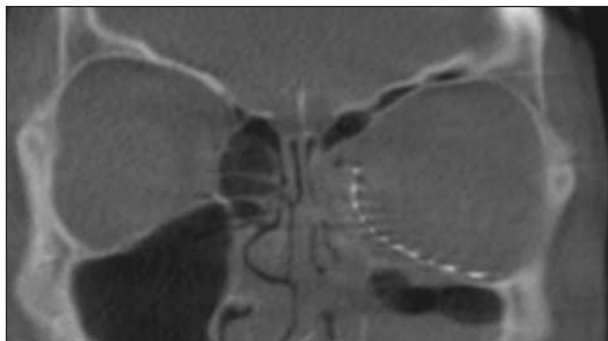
Postoperative cone beam computed tomographic scan of the patient in Figure 7 after insertion of the titanium mesh in the left orbit.
